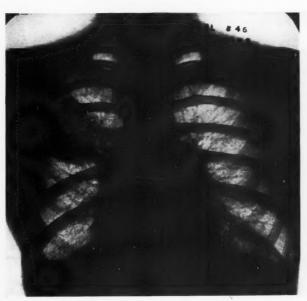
Radiograph showing that, although the patient has recovered completely from the mediastinal and pleural complications of the ruptured œsophagus, an acute abscess has developed in the right upper lobe of the lung.
